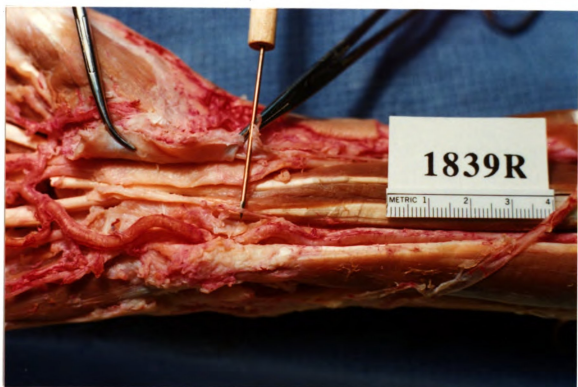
Small Branch of the Ulnar Artery within the CT
